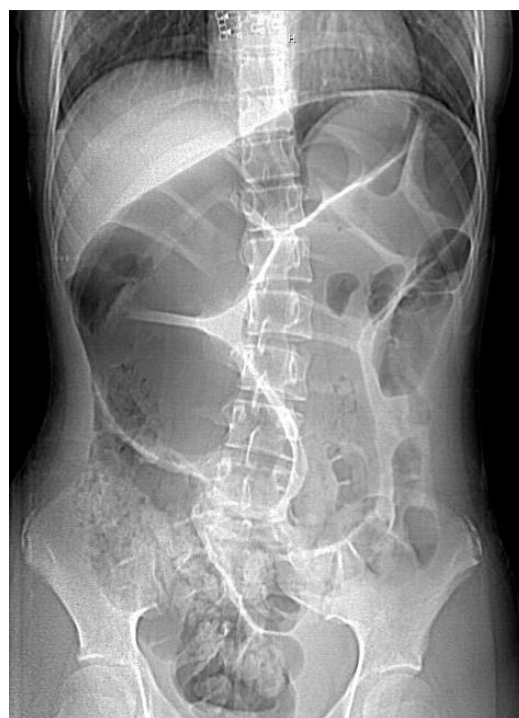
Abdominal radiograph demonstrating distended bowel
